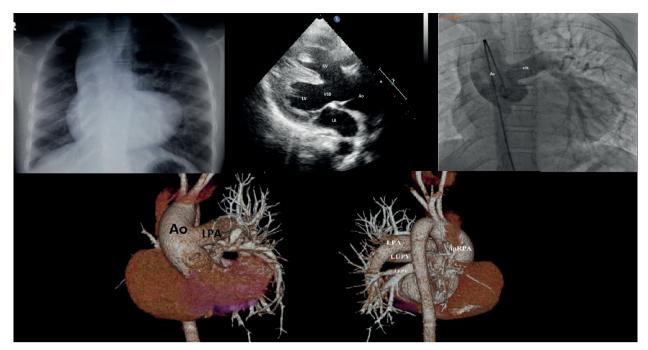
A. Chest X-ray showing levocardia, a boot-shaped heart, and an absent pulmonary artery segment. B. Two-dimensional echocardiographic study showing a large misaligned subaortic ventricular septal defect with aortic overriding. C. Ascending aortogram in anteroposterior view showing the left aortic arch, the origin of the left pulmonary artery from the aorta, and the absence of the right pulmonary artery. D. Computed tomography angiography image anterior view showing an anomalous left pulmonary artery arising from the proximal ascending aorta. E. Computed tomography angiography image posterior view showing the intraparenchymal right pulmonary artery branches
